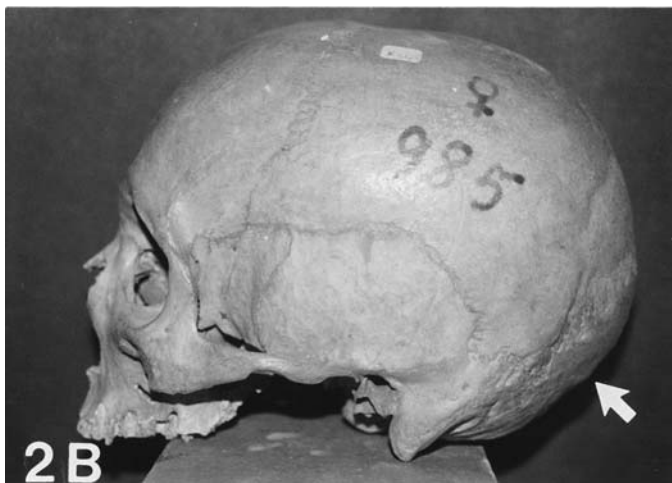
Smooth form (Type 1) of the external occipital protuberance (arrow). A) Lateral cranium radiograph. B) Dry skull photograph.
